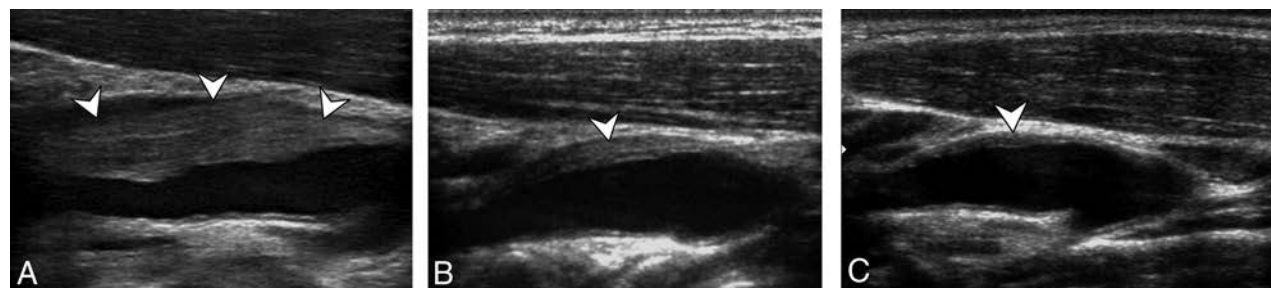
Initial diagnostic ultrasonography (A) and follow-up ultrasonography at 14 days (B) and 6 months (C) show a perivascular infiltration (arrowheads) at the level of the internal carotid artery just at the level of bifurcation, with a quick decrease at 14 days and the persistence of a thin abnormality at 6 months.
